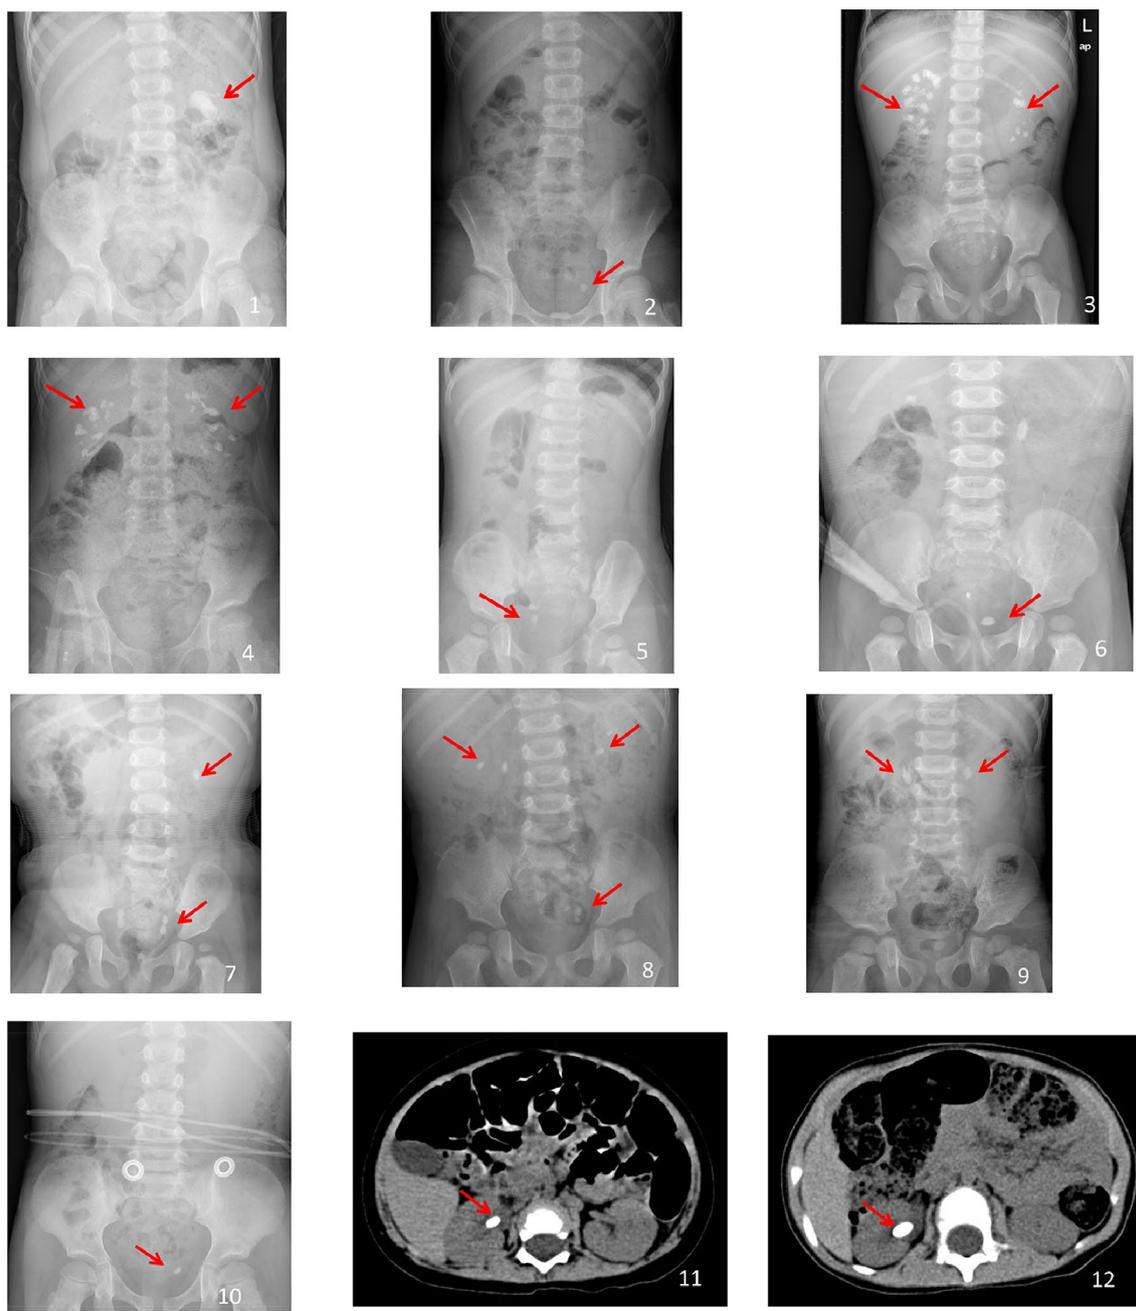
Kidney, ureter and bladder (KUB) radiographs or computer tomography of patients 1–12
